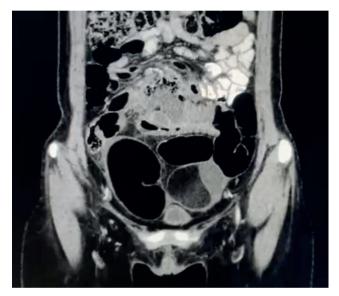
Case of surgically and pathologically confirmed endometrioma. CT images showing a large lesion in the pelvis in which the significant perilesional inflammatory reaction is evident.
